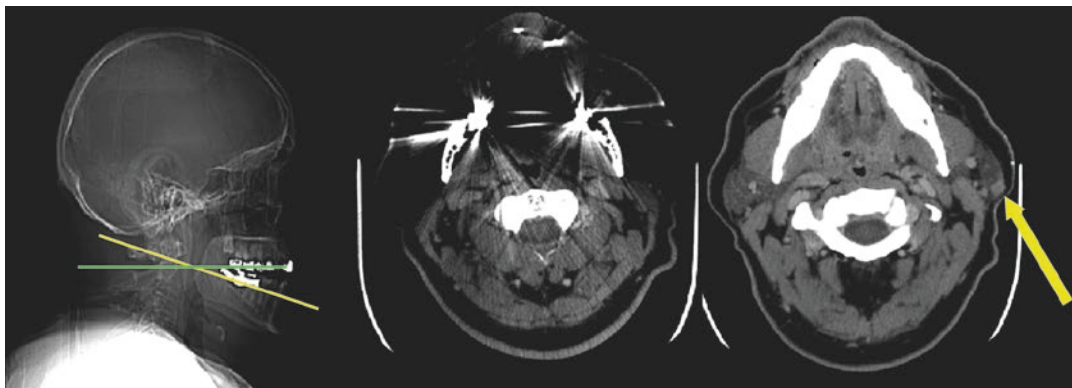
This 70-year-old man had undergone Mohs surgery for a left preauricular squamous cell carcinoma 4 months prior to this CT. *Left:* The lateral scout image shows the planes of the axial images. *Middle:* The left
